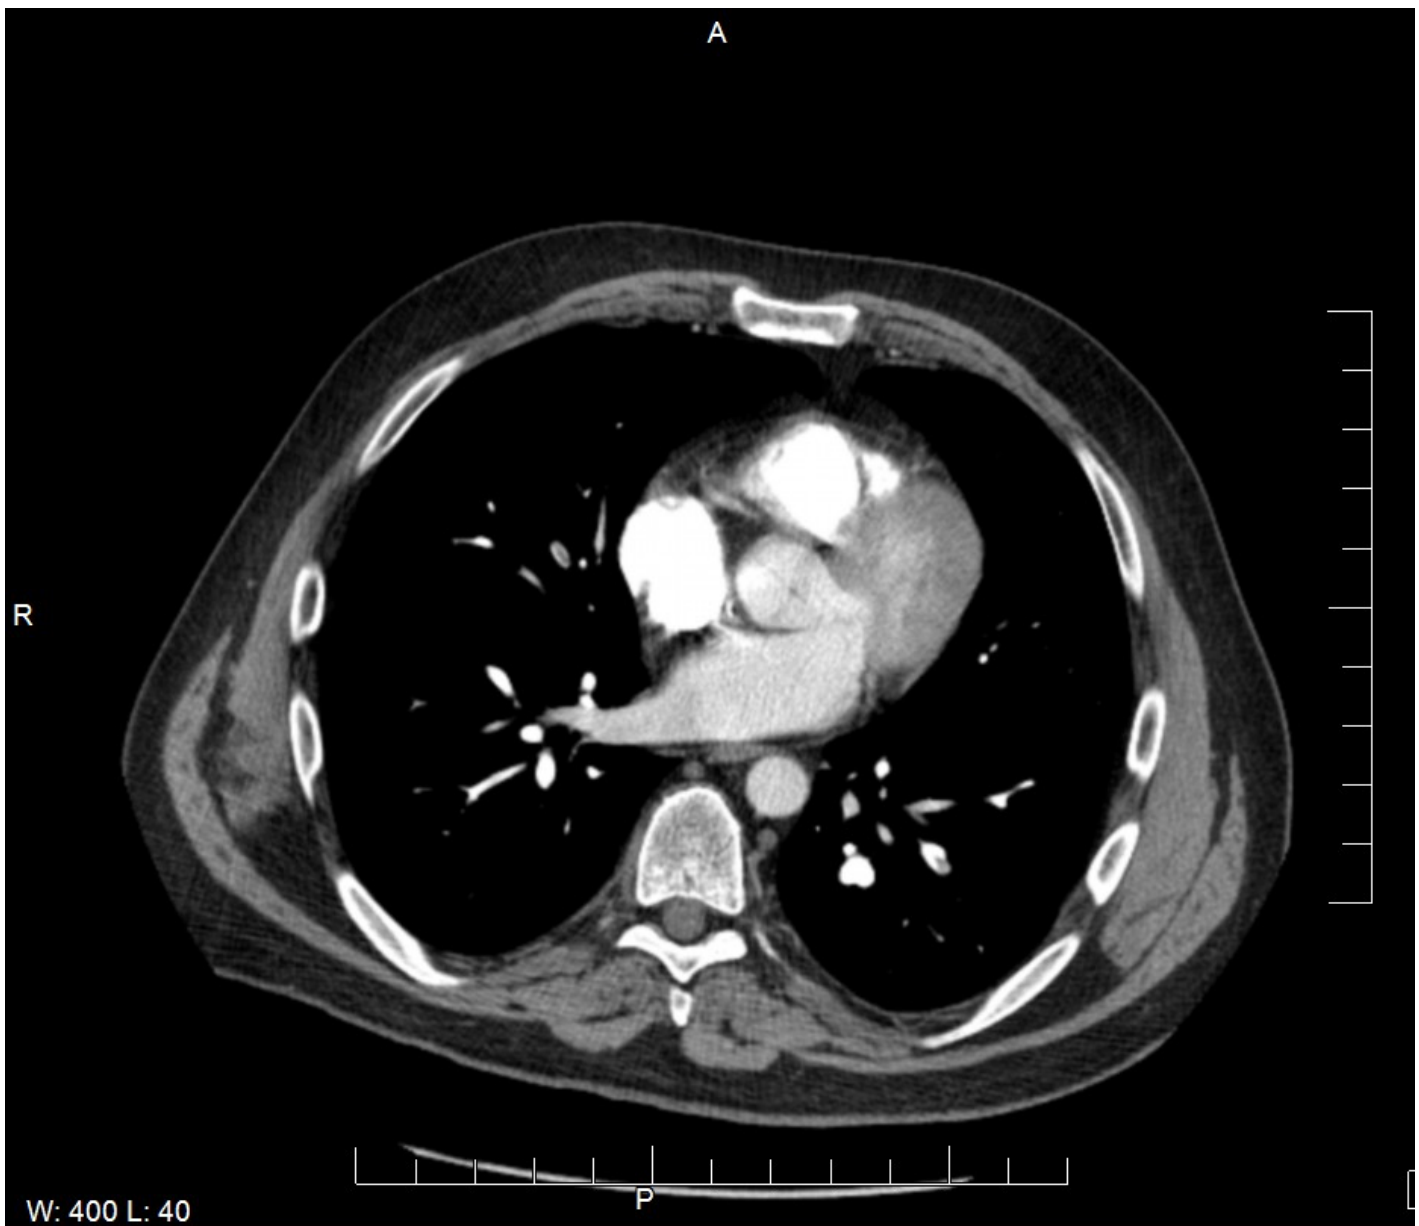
Computed Tomography (CT) Pulmonary Angiogram Demonstrating Pulmonary Embolism. Axial CT pulmonary angiogram image dated November 9, 2021, showing multiple small pulmonary emboli in the segmental and subsegmental branches of the left pulmonary artery. The emboli appear as intraluminal filling defects within contrast-opacified pulmonary arteries, consistent with acute pulmonary embolism. This diagnosis occurred approximately eight months following the patient's second dose of the Pfizer-BioNTech COVID-19 mRNA vaccine.
